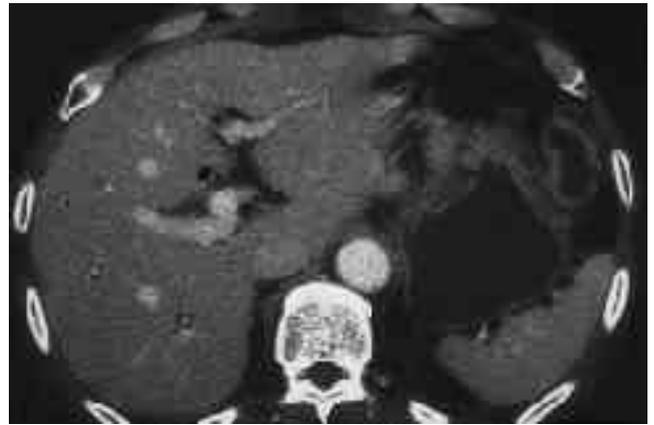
Eleven months follow up abdominal CT in 46-year-old male after gastro- jejunostomy. CT scan demonstrate dilatation of peripheral portion of intrahepatic bile duct.(arrow head) and mild dilatation of central portion of intrahepatic duct(arrow).
